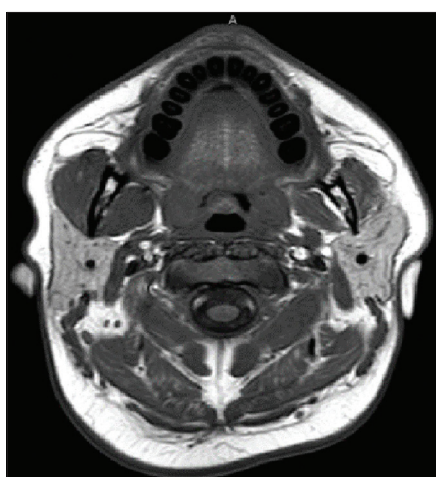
Mandibular and muscular atrophy figure description: contrasted T1-weighted magnetic resonance imaging demonstrates asymmetric of the mandibular rami, with left smaller than right, as well as atrophy of the muscles of mastication.
